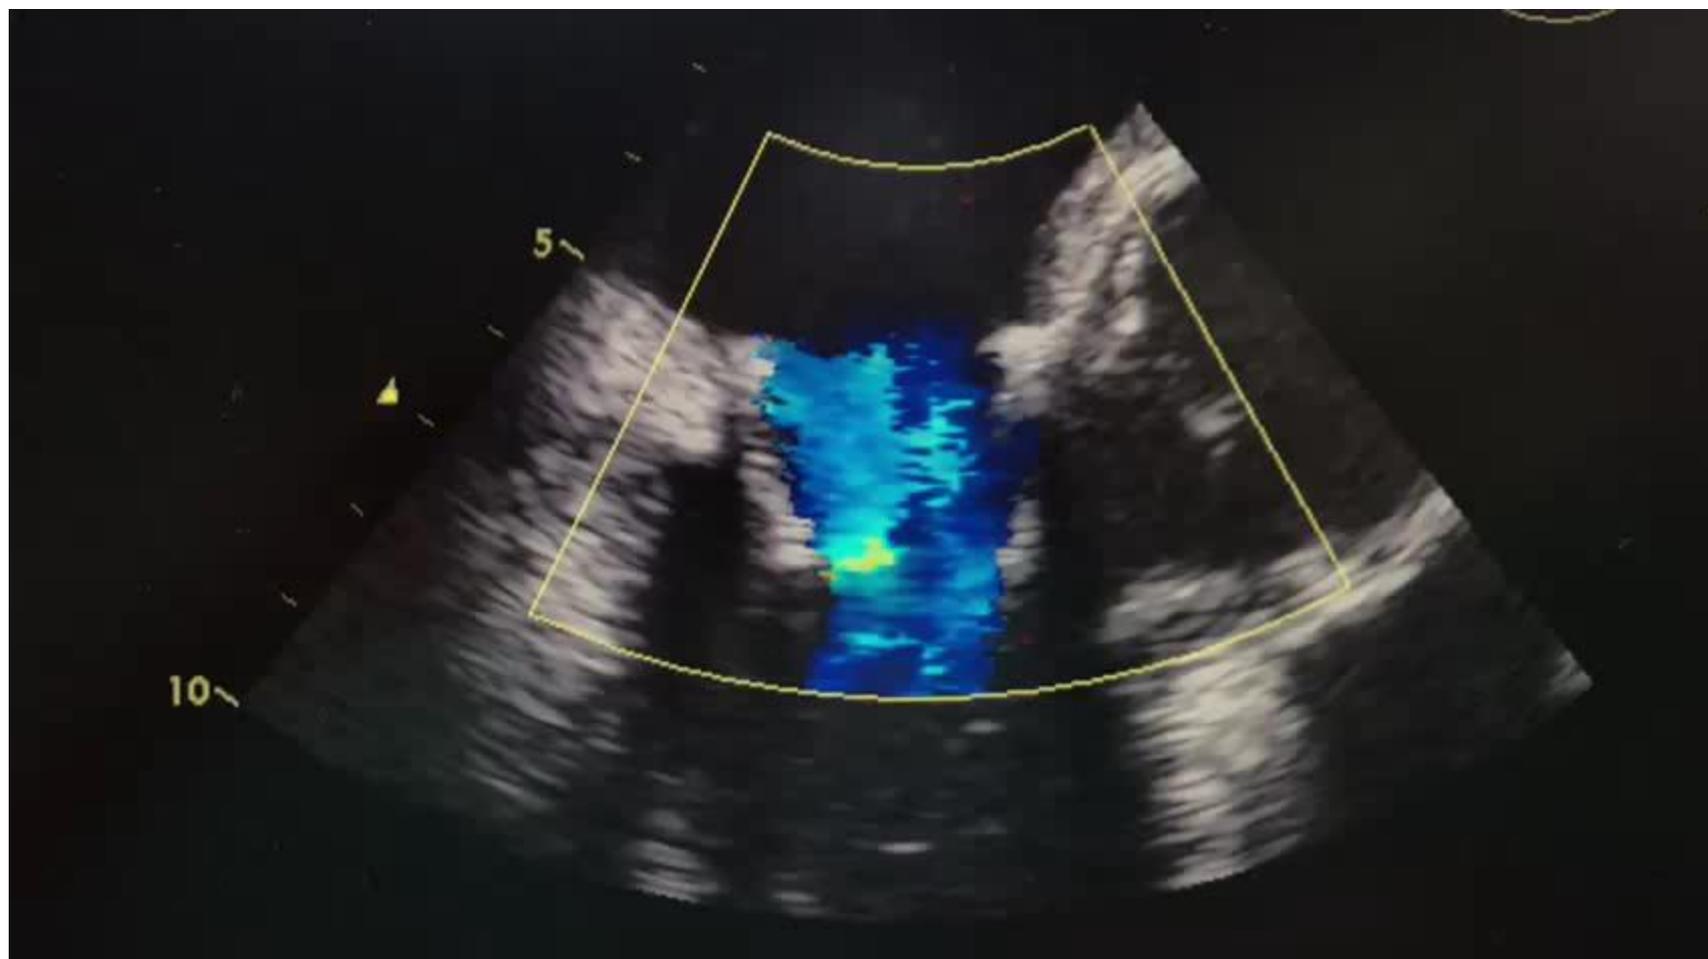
a,b Two two-dimensional transesophageal images (at the mid-esophageal level) with an angle of 120–130° and anticlockwise rotation until the ultrasound beam does not cross a tangential plane of the LAA. The
